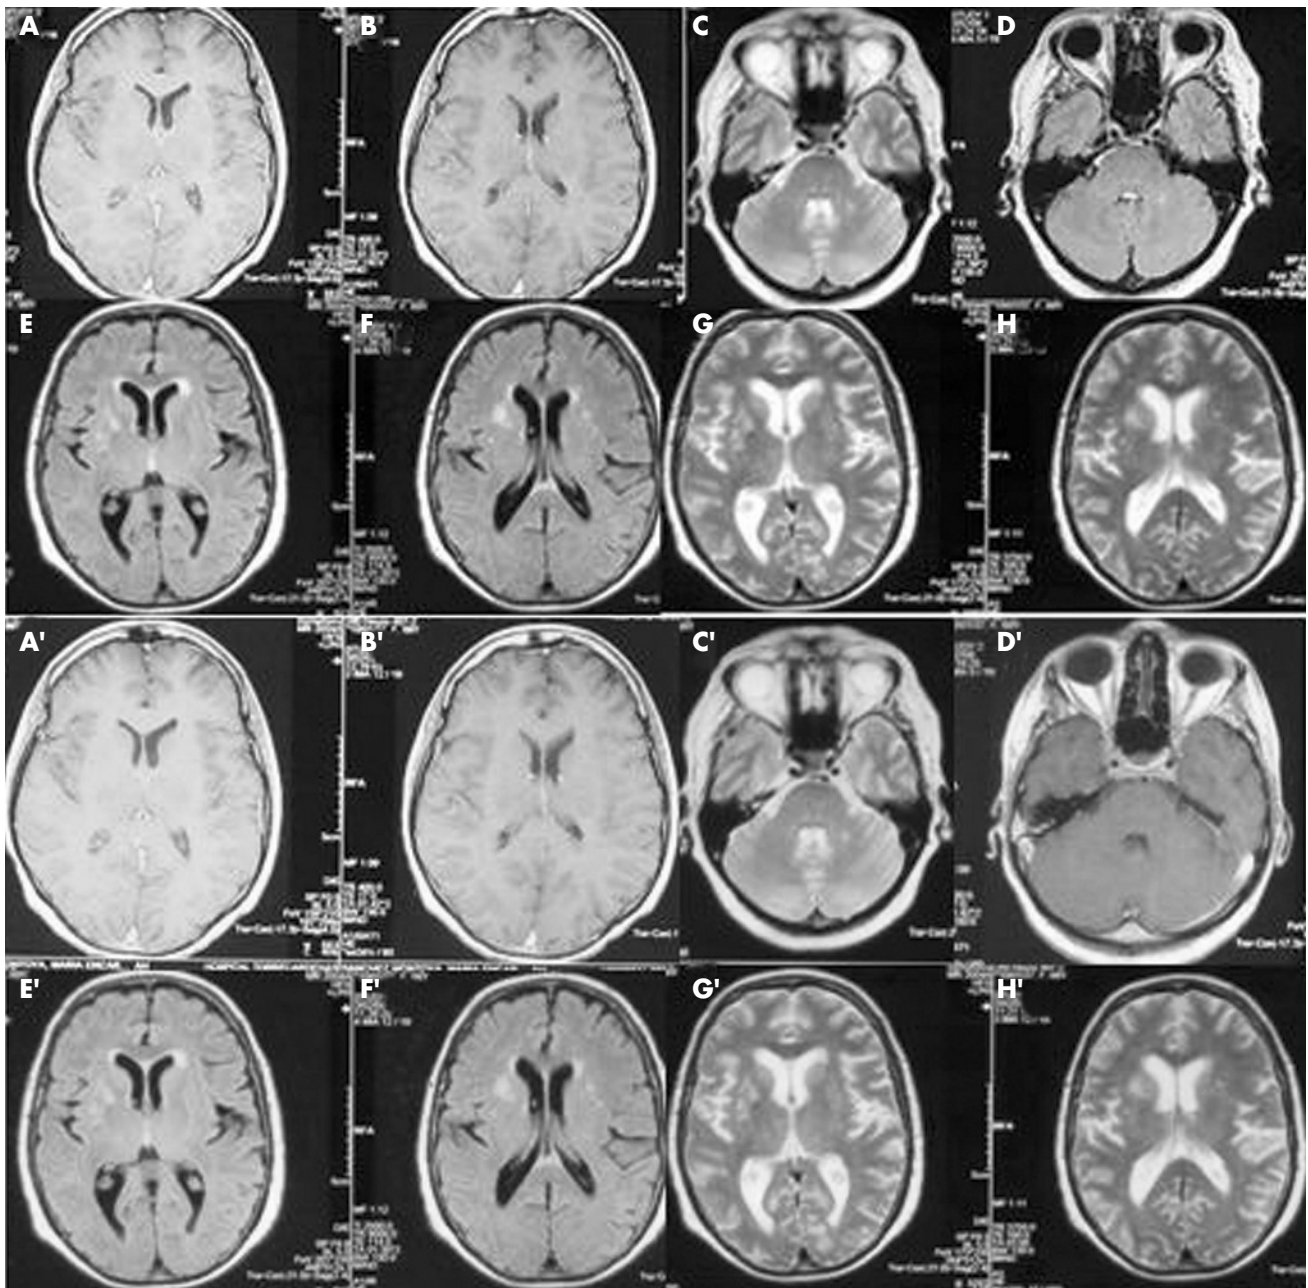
(A,B) Normal post-gadolinium T1. (C) Left middle cerebellar peduncle T2 lesion, (D) enhancing T1. (E–H) Bilateral striatal hyperintense lesions (right predominant) in fluid-attenuated inversion recovery (E, F) and T2 (G,H). (A'–H') MRI after 6 months. The only clear difference is absence of enhancement in the left middle cerebellar peduncle post-gadolinium T1 (D').
